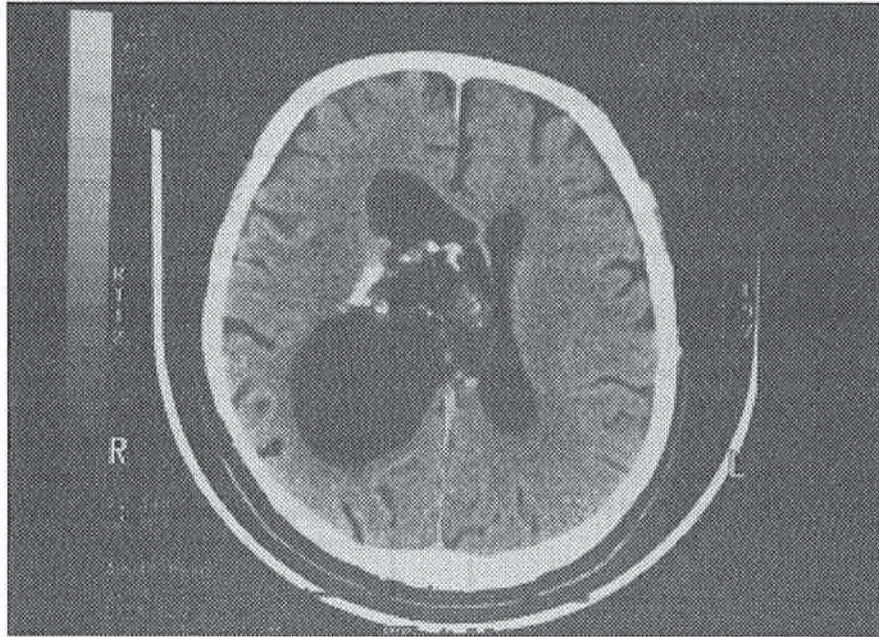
Non enhanced axial CT section at the level of the lateral ventricle shows a partially calcified mass near the foramen of Monro with cystic and solid areas and dilatation in the right lateral ventricle.
